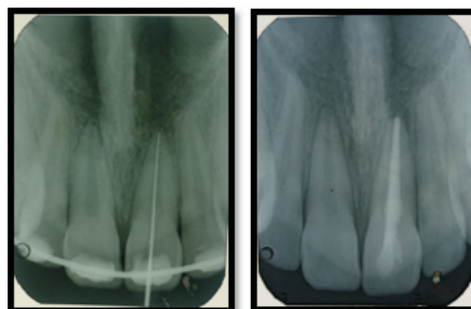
Working length and Post obturation Radiograph
